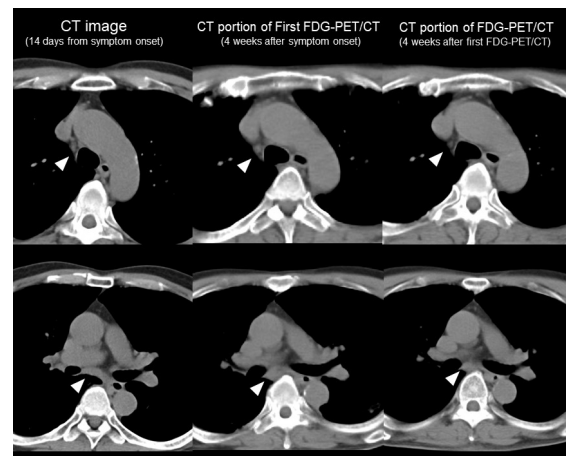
Change of CT feature of lymph node over time. Left side: CT image (14 days from symptom onset), Middle: CT portion of FDG-PET/CT (4 weeks after symptom onset), Right side: CT portion of second FDG-PET/CT (4 weeks after first FDG-PET/CT examination). CT image (14 days from symptom onset) showed no evidence of mediastinal lymph node swelling (arrowhead). Although the size of the lymph node is not significant, it was increased compared to 2 weeks from CT imaging and decreased within 4 weeks after the first FDG-PET/CT examination.
